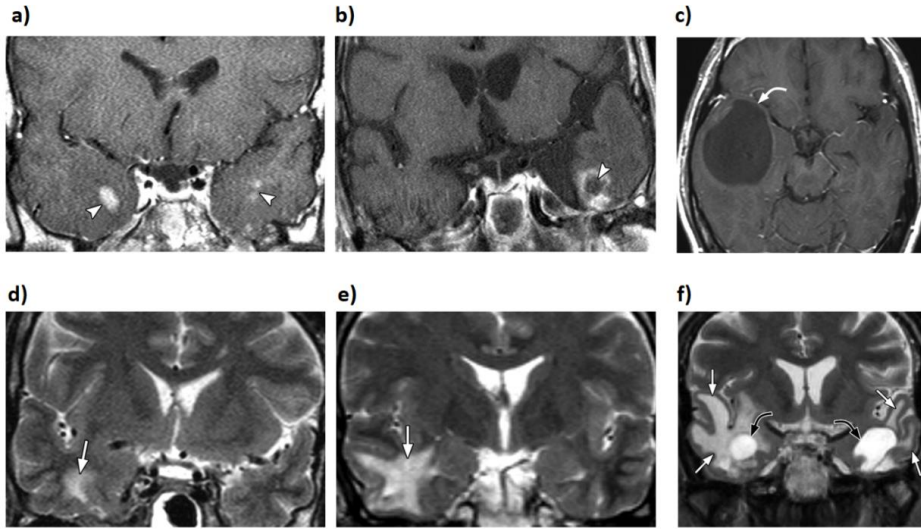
Manifestations of radiation necrosis on post contrast T1 weighted MRI sequences on the top row and T2 weighted sequences on the bottom row: a) bilateral contrast enhanced solid nodules, b) contrast enhanced nodule with central necrotic region, c) cyst with low signal intensity including slight rim enhancement, d) small white matter lesion, e) medium sized white matter lesion and f) white matter lesions (white arrows) and cysts (black arrows). Images from Wang et al. (101) (reused with permission).
